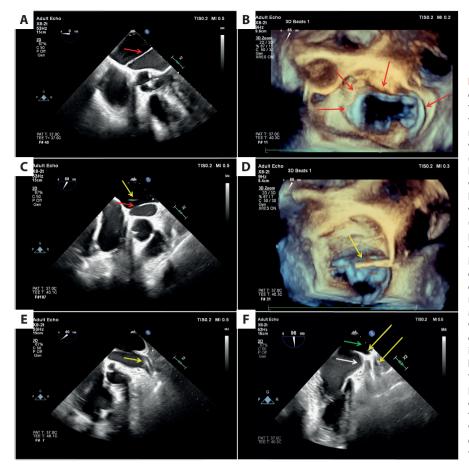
2D/3D transesophageal echocardiography (TEE) images of the membrane in the left atrium and transseptal puncture. A. A 2D TEE midesophageal (ME) five-chamber view of the left atrium membrane (red arrow). B. A 3D TEE image of the left atrium membrane (red arrows) with mitral valve leaflets in the background. C. A 2D TEE ME aortic valve short-axis view of the guide wire (yellow arrow) in the posterior compartment of the left atrium, behind the membrane (red arrow). D. 3D TEE image of the transseptal sheath and guide wire (foreground, yellow arrow) over the left atrial membrane and mitral valve (background). E. A 2D TEE ME two-chamber view of the guide wire (yellow arrow) in the anterior compartment of the left atrium heading towards the left atrial appendage. F. A 2D TEE ME two-chamber view of the guide wire (yellow arrows) in the posterior compartment of the left atrium (green arrow) heading towards the left superior pulmonary vein. The white arrow indicates the anterior compartment of the left atrium with the appendage
